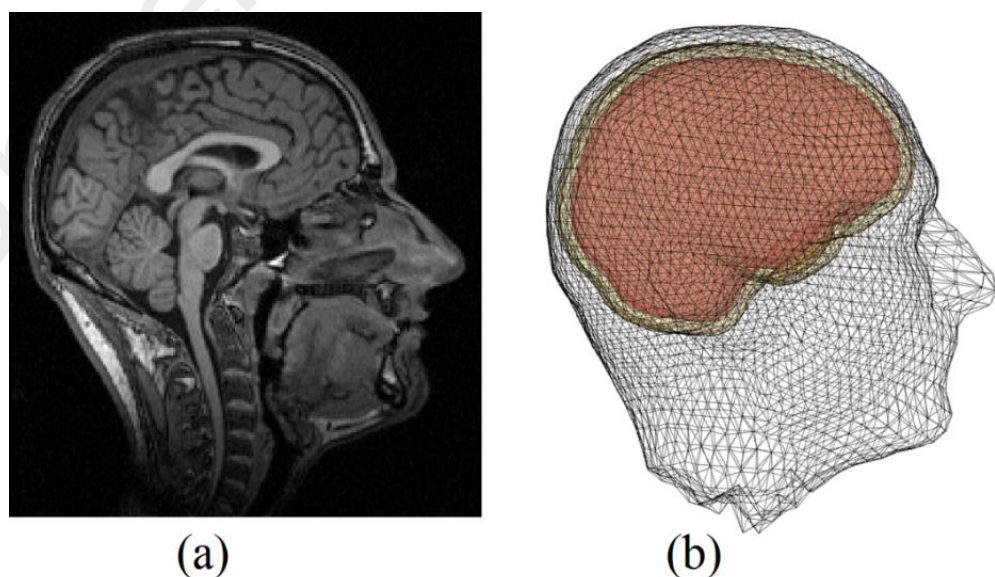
(a) MRI scan of a subject. (b) BEM meshes of brain, skull and scalp of the same subject.
